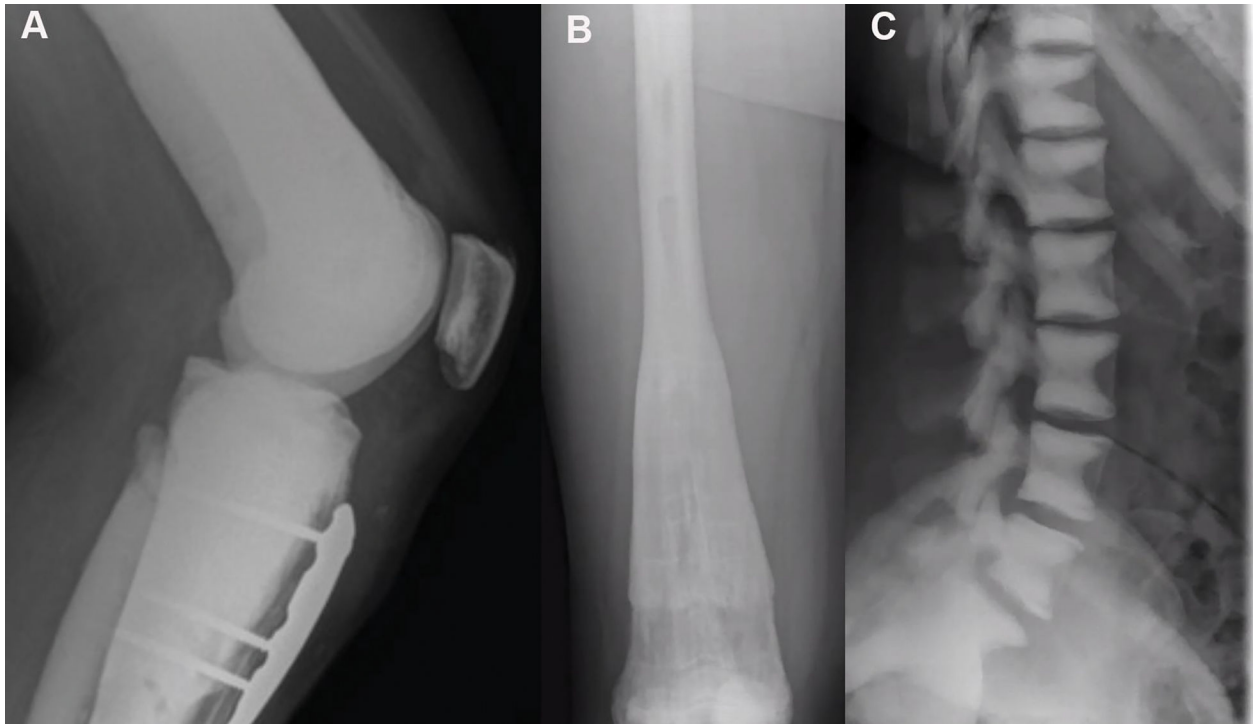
Classic radiographic features of osteopetrosis:
